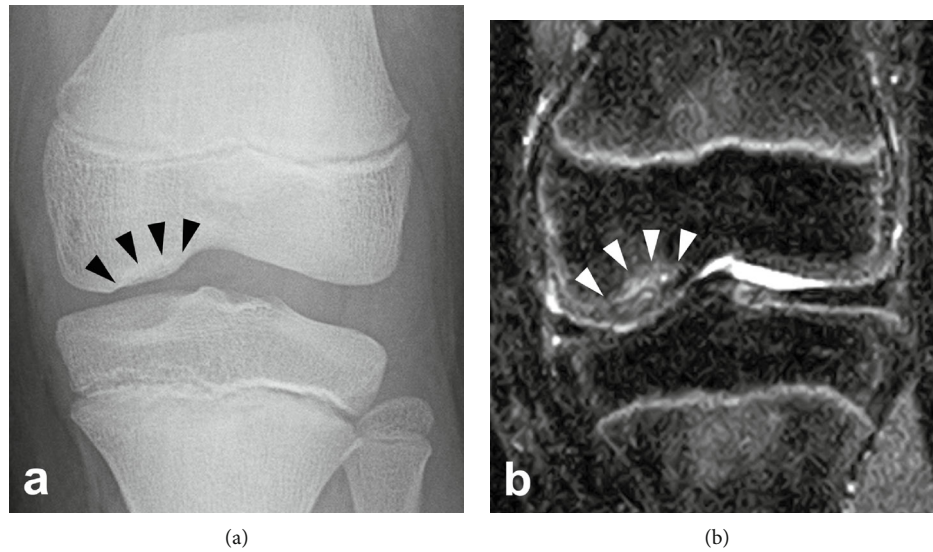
(a) Radiograph of the left knee showing Brückl's stage III OCD lesion in the MFC. (b) Short T1 inversion recovery (STIR) sequence MRI coronal image of the left knee indicating Nelson's stage II lesion in the MFC.
